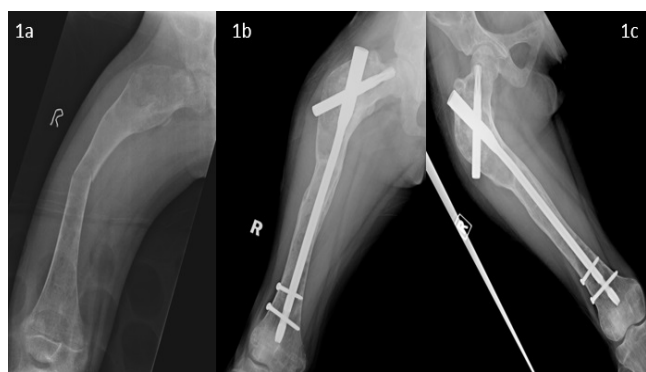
Initial plain radiograph (1a) shows expansile lytic lesion of the proximal right femur with ground glass opacities and present of mid femoral fracture. On subsequent follow-up (1b & 1c), the lytic lesion appears to be reducing in size and increased in the bone density as well as appear to be more homogenous. The fracture line had disappeared on the latest radiograph.
